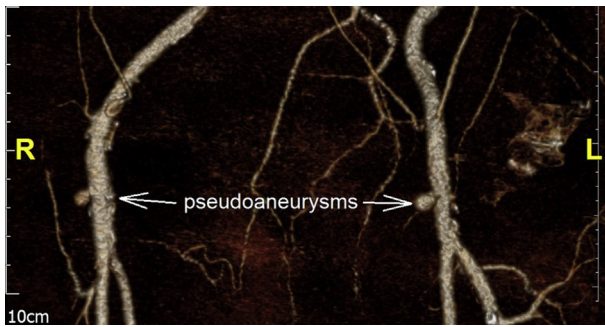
Representative small luminal aspects of femoral pseudoaneurysms (volume-rendered CT reconstruction).
